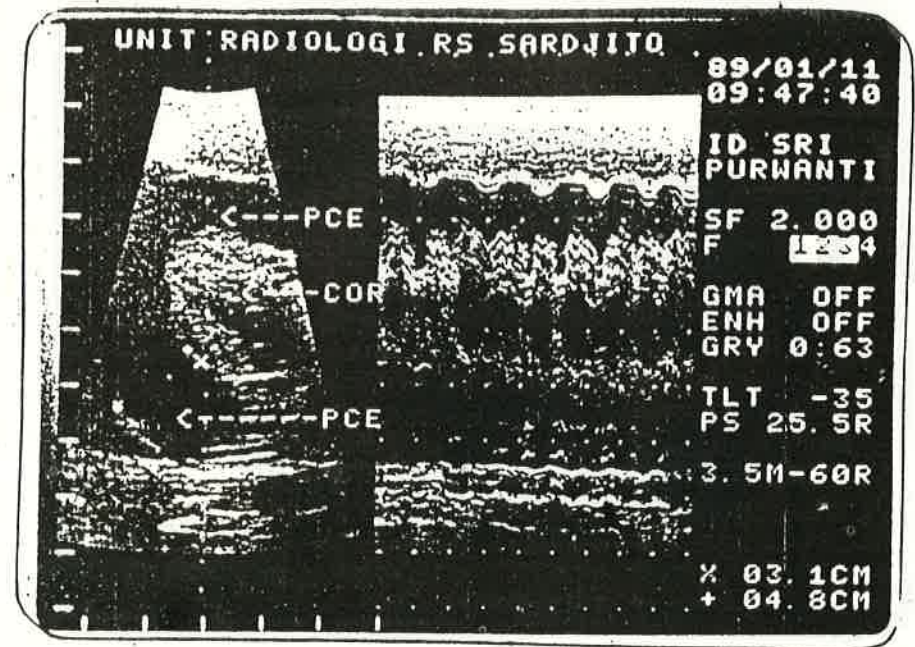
Echocardiogram demonstrating large anterior and posterior pericardial effusions prior to pericardial tap
